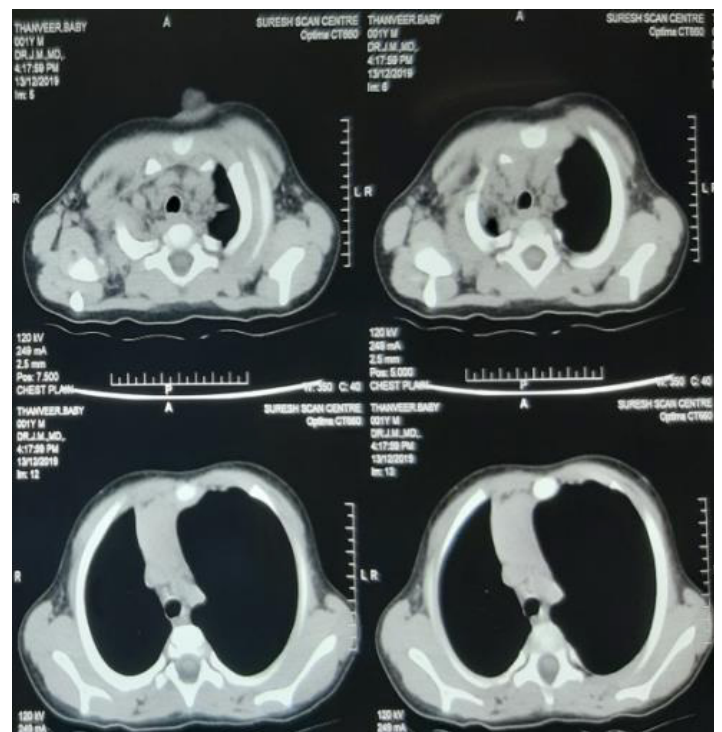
CT Chest shows hyperinflated left lung with trachea shift to the right side due to FB
